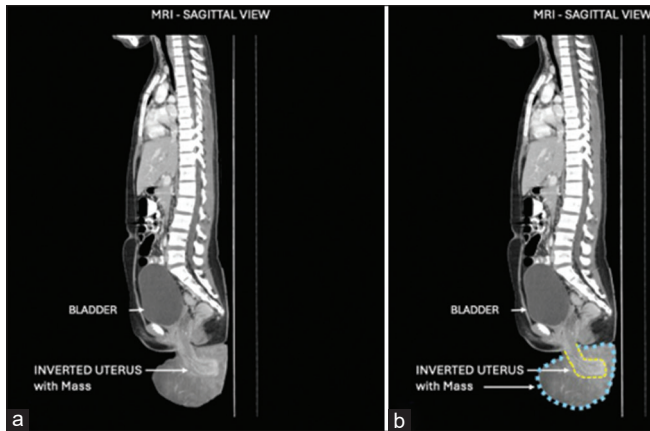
Magnetic resonance imaging images. (a) Sagittal view demonstrating an inverted uterus. (b) Yellow dotted lines delineate the uterine corpus, and blue dotted lines delineate the irregular mass
